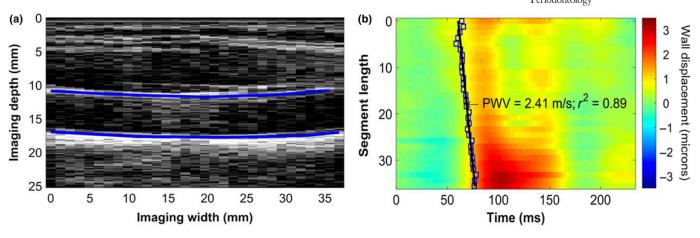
(a) Ultrasound tracing of a representative high quality capture of the carotid artery. The vessel walls are well-defined and easy to demarcate. (b) Spatio-temporal map from a vessel with homogenous transmission of the pulse wave
